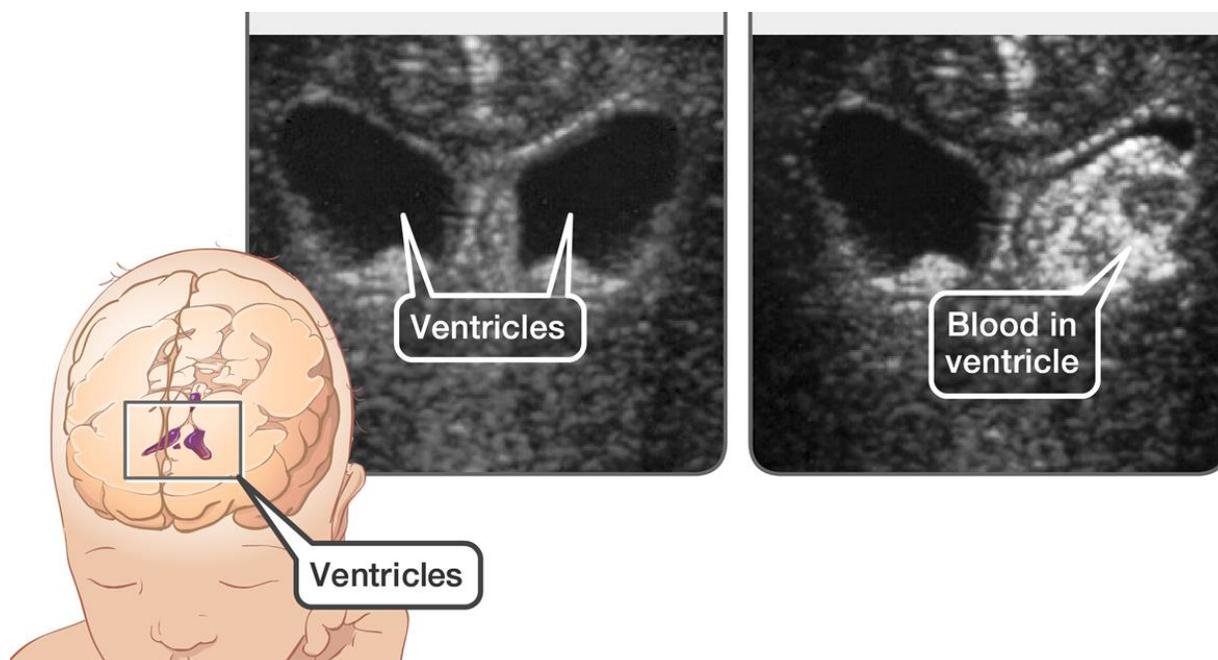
Healthy and IVH CT scans of the neonate ventricles with an anatomical reference on the left [17].
